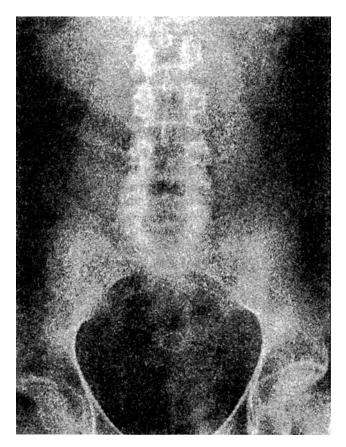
Plain x-ray of the abdomen. Note the stapled ring anastomosis.
